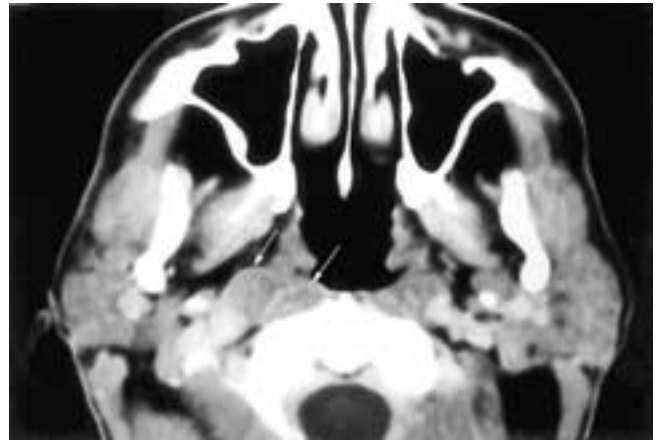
Axial contrast-enhanced CT scan shows enlarged medial and lateral right retropharyngeal lymph nodes with an attenuation slightly less than that of muscle (arrows). This patient had large cell lymphoma.
